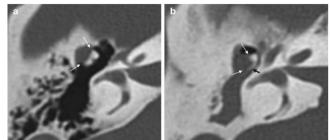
Axial CT-image of a right ear: (a) condensation of the lateral attic with slight mass effect on the incudomalleal chain (arrows), (b) atticoantral condensation with a prominent mass effect on the incudomalleal chain (white arrows), and advanced lysis of the incus (black arrow)^[29].
